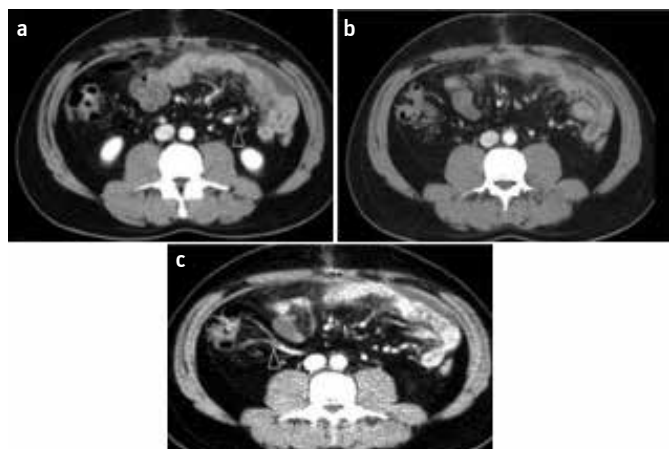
a-c. Axial slices of CT exam revealed an agglutination of intestinal loops in the left hemiabdomen and a low amount of subparietal ascites (a), associated with a misty appearance of the mesenteric fat, taking the appearance of a fatty pseudomass (b) due to the dominant pathologic component (fat necrosis). Note the stretched and prominent appearance of mesenteric vessels (arrowheads) (a, c).
